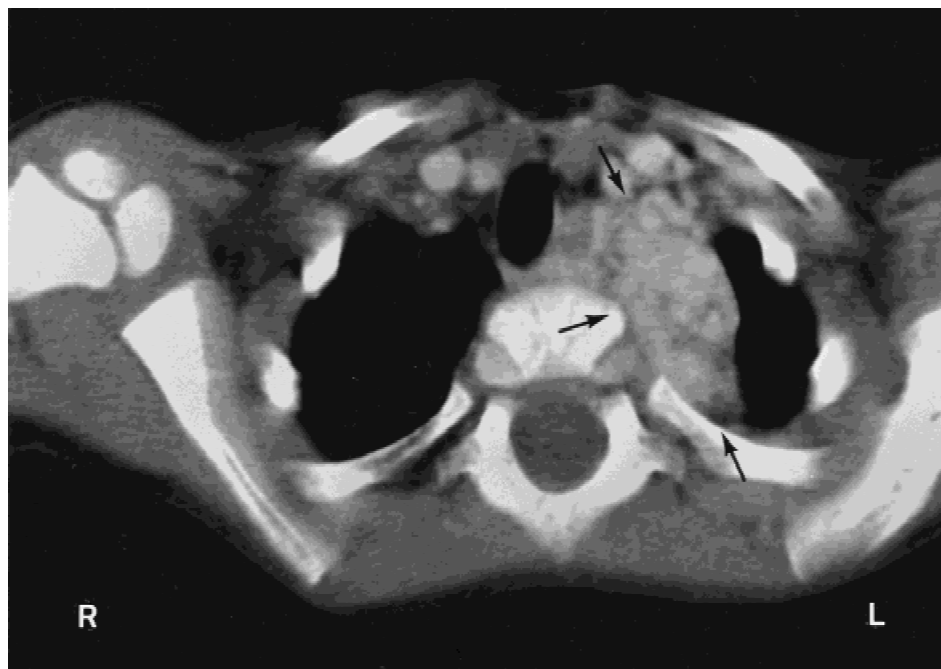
Contrast-enhanced thoracic CT-scan: an infiltrative, contrast-enhanced, solid mass is located in the left posterior mediastinum (black arrows).
